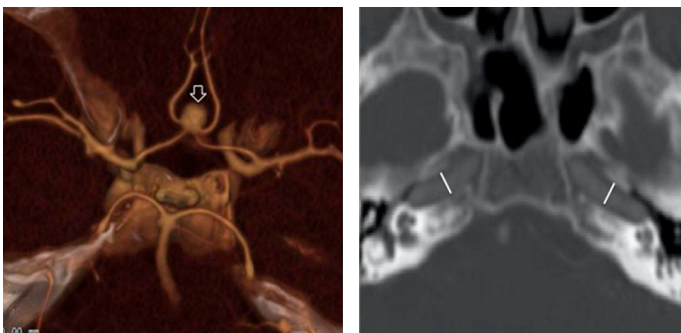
36-year-old man with anterior communicating artery aneurysm. Volume rendering image shows anterior communicating artery aneurysm (a). Axial CT image (b) shows widening of the carotid canal.
